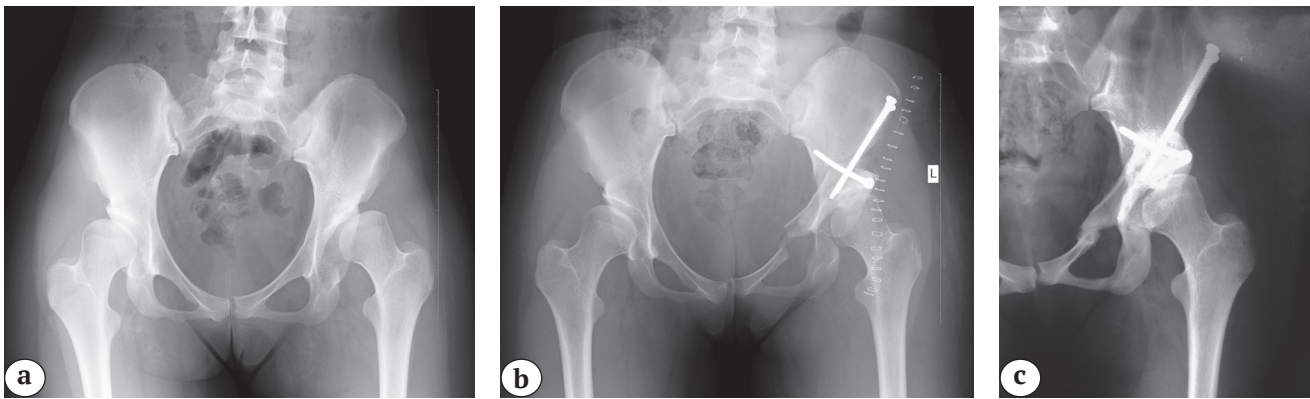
X-rays of the 19-year-old patient:
